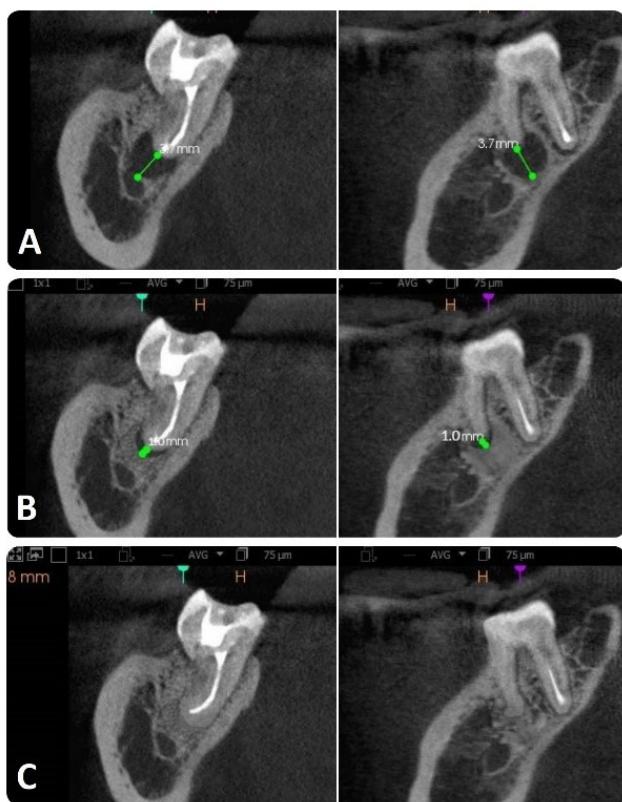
Cone-beam computed tomography (CBCT) imaging of tooth 47 (FDI World Dental Federation classification)
